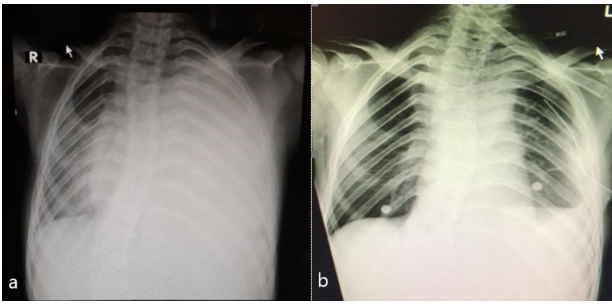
Chest X-ray showing a blunt area on the left side of the chest (a). Chest X-ray after thoracocentesis (b).
